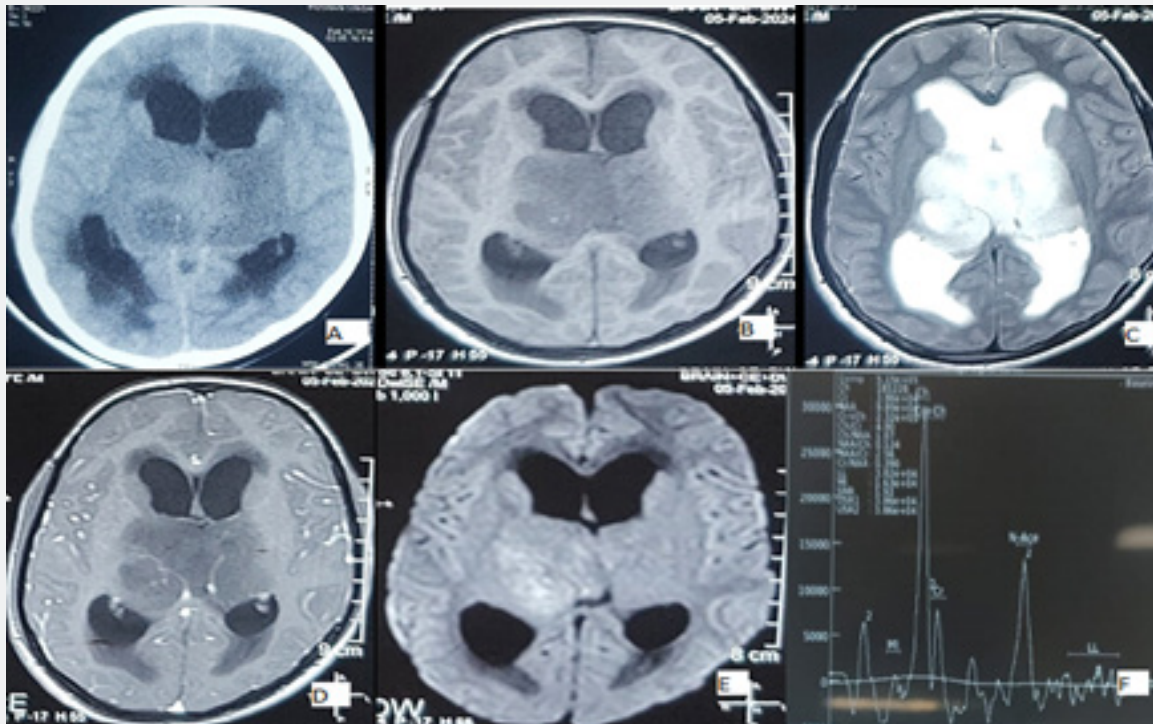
(A) non-enhancing hypodense enlarged thalami bilaterally, with involvement of midbrain on CT. MRI shows lesion involving bilateral thalami, adjacent part of basal ganglia, right half of mid brain, foramen of monro, causing compression of aquaduct of sylvius, resulting in moderate dilatation of lateral & 3rd ventricles, appearing hypointense on T1W (B) while hyperintense on T2W & FLAIR images (C), shows patchy restriction on DWI(E) with no obvious blooming on GRE (D) with significantly elevated choline peaks with mildly reduced creatine and NAA peaks (F).
